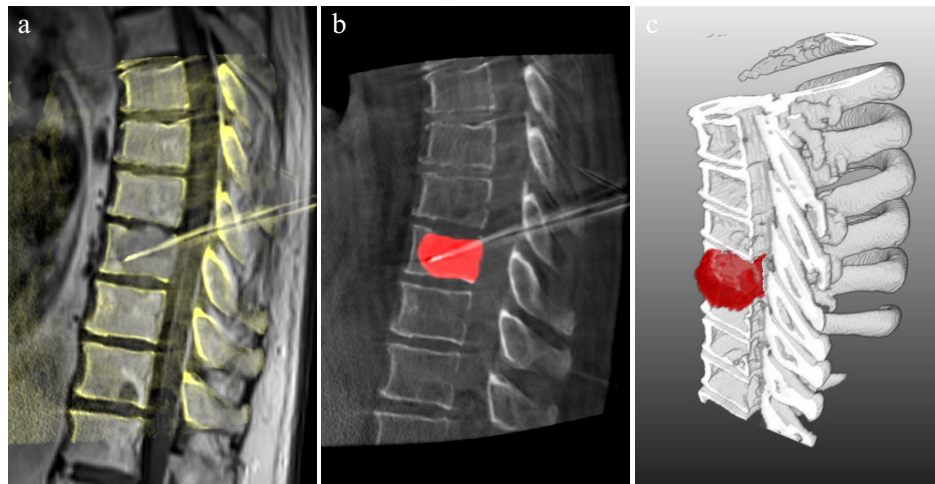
Image fusion of pre- and intra-operative images represents a significant improvement of the interventional routine. As a result of the image registration (left; background: MRI, overlay: FP-CT) a transformation matrix could be used to transfer and display pre-interventionally produced information like contoured metastases within the intra-interventional images (middle, right).
